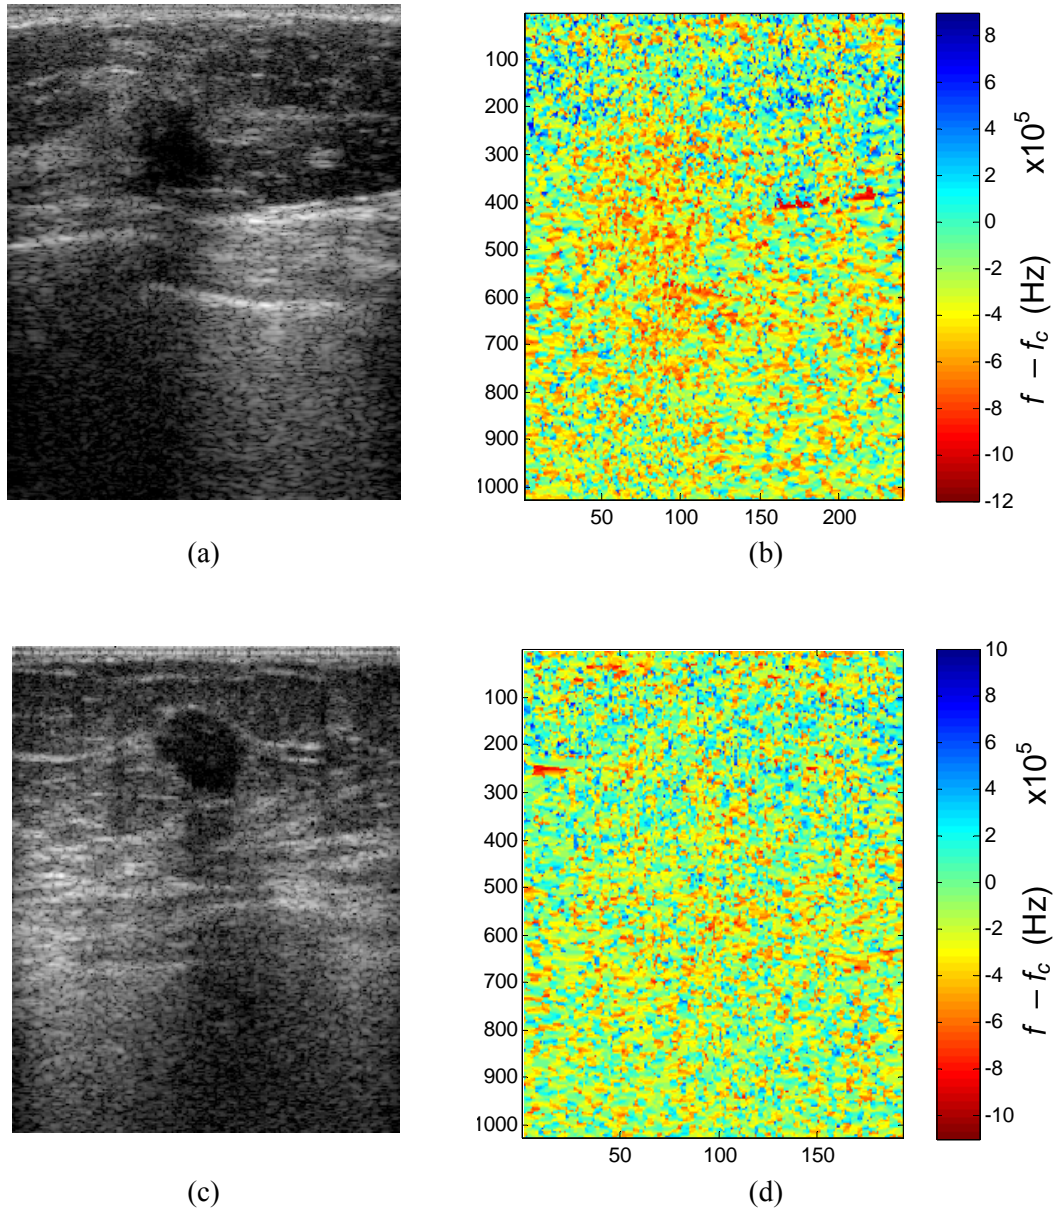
B-mode image (left) and magnitudes of the spectral peak shift across the ultrasound scan plane (right) for clinical case #16 (ILC, cf. annex II) at the top and for clinical case #1 (DCIS, cf. annex II) at the bottom (centre-frequency $f_c = 8.3\text{MHz}$).
